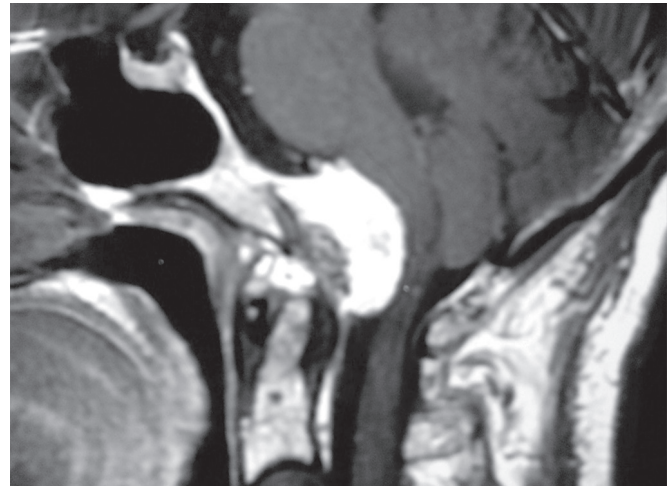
Sagittal T1-weighted magnetic resonance imaging (MRI) image showing a foramen magnum meningioma.
